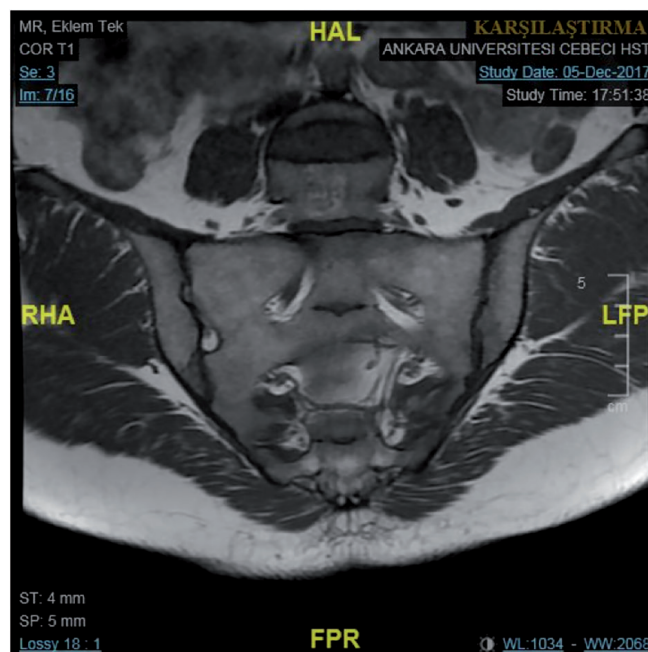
T1 coronal MRI of the sacroiliac joint, bilateral focal erosive changes and minimal sclerosis.
